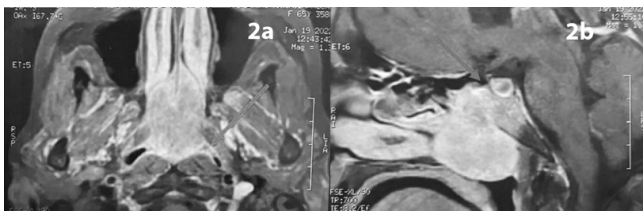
2a: Nasopharyngeal MRI in axial section, T1-weighted image: showing the enhanced nasal tumor, filling the nasopharynx without parapharyngeal extension (arrow)
